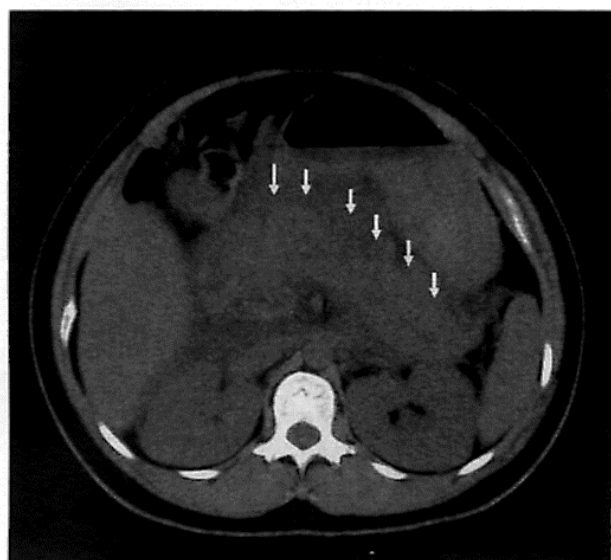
Noncontrast CT showed peripancreatic inflammation from head to tail and fluid collection (arrow head).
